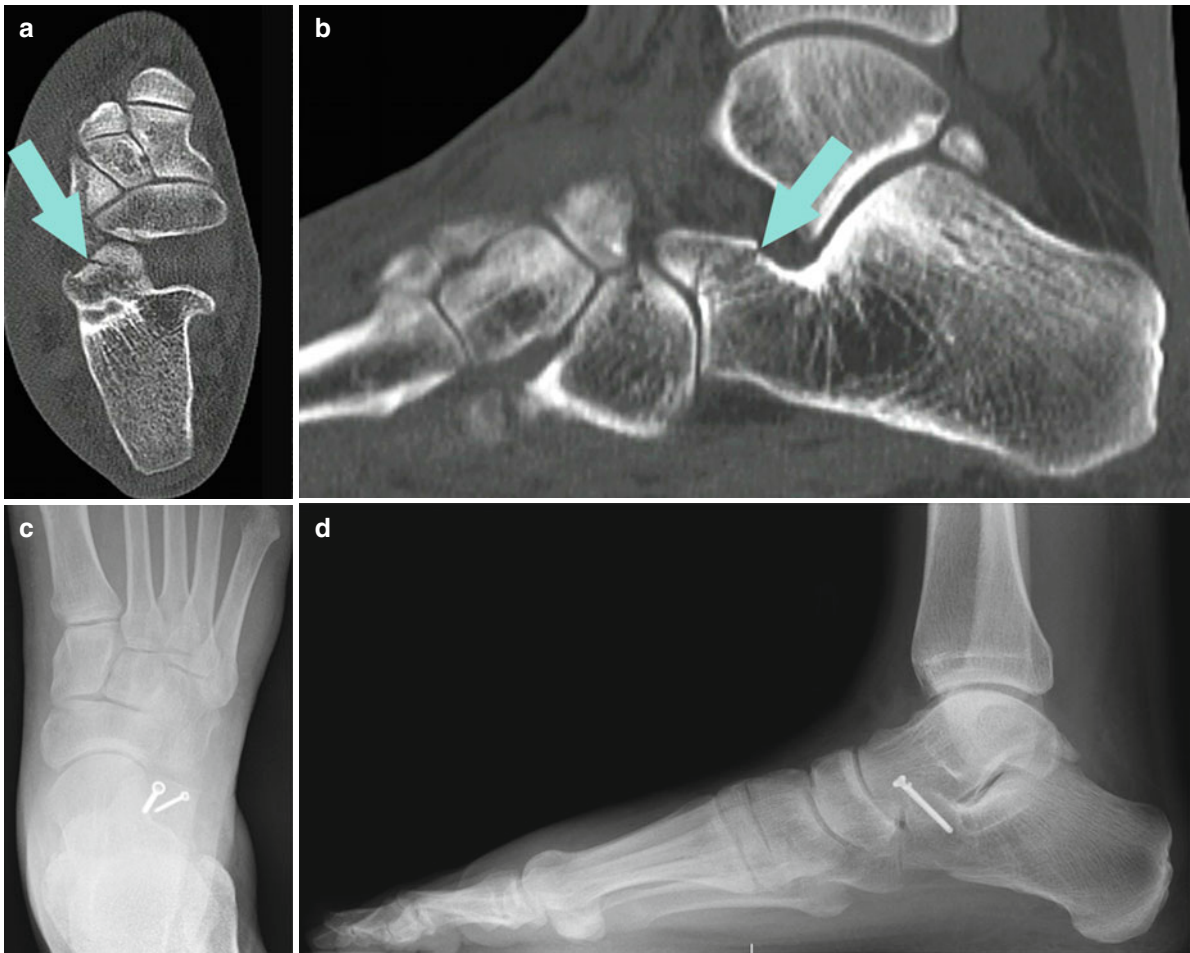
Preoperative axial (a) and lateral (b) CT scans of an anterior process fracture (arrow in a and b) of the calcaneus are shown, which has been open reduced and fixed with two screws (c, d)
